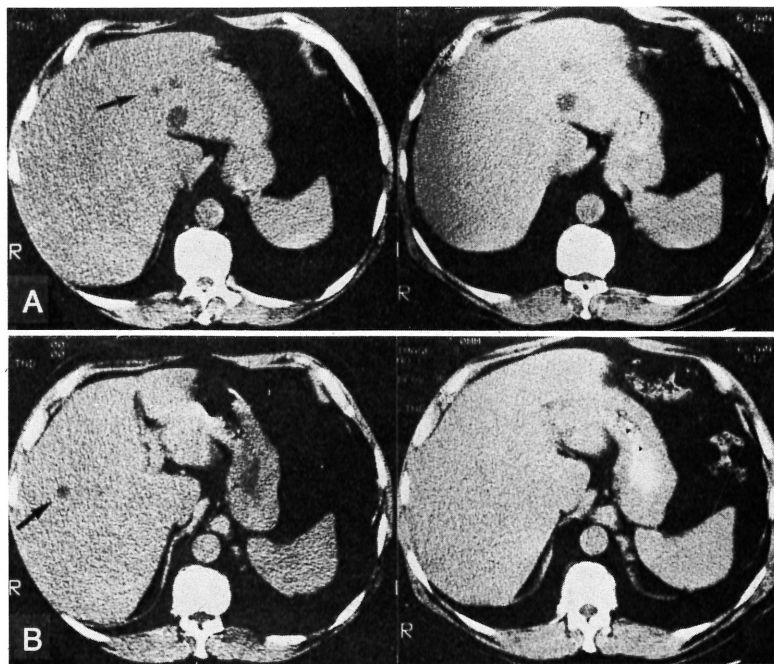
Two representative CT scan sections of patient 6 with multiple hepatic metastases before treatment (A) and 1 month after treatment (B). Complete disappearance of two small metastatic deposits is indicated by arrows.
